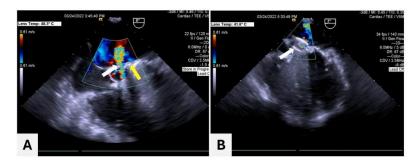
Transesophageal echocardiography (TEE) of the patient (A) Pre-procedure TEE showing a mitral paravalvular leak (white arrow) prosthetic mitral valve (yellow arrow). Post-procedure TEE showing the well-positioned MFO device at the mitral area with no evidence of leakage (white arrow).
